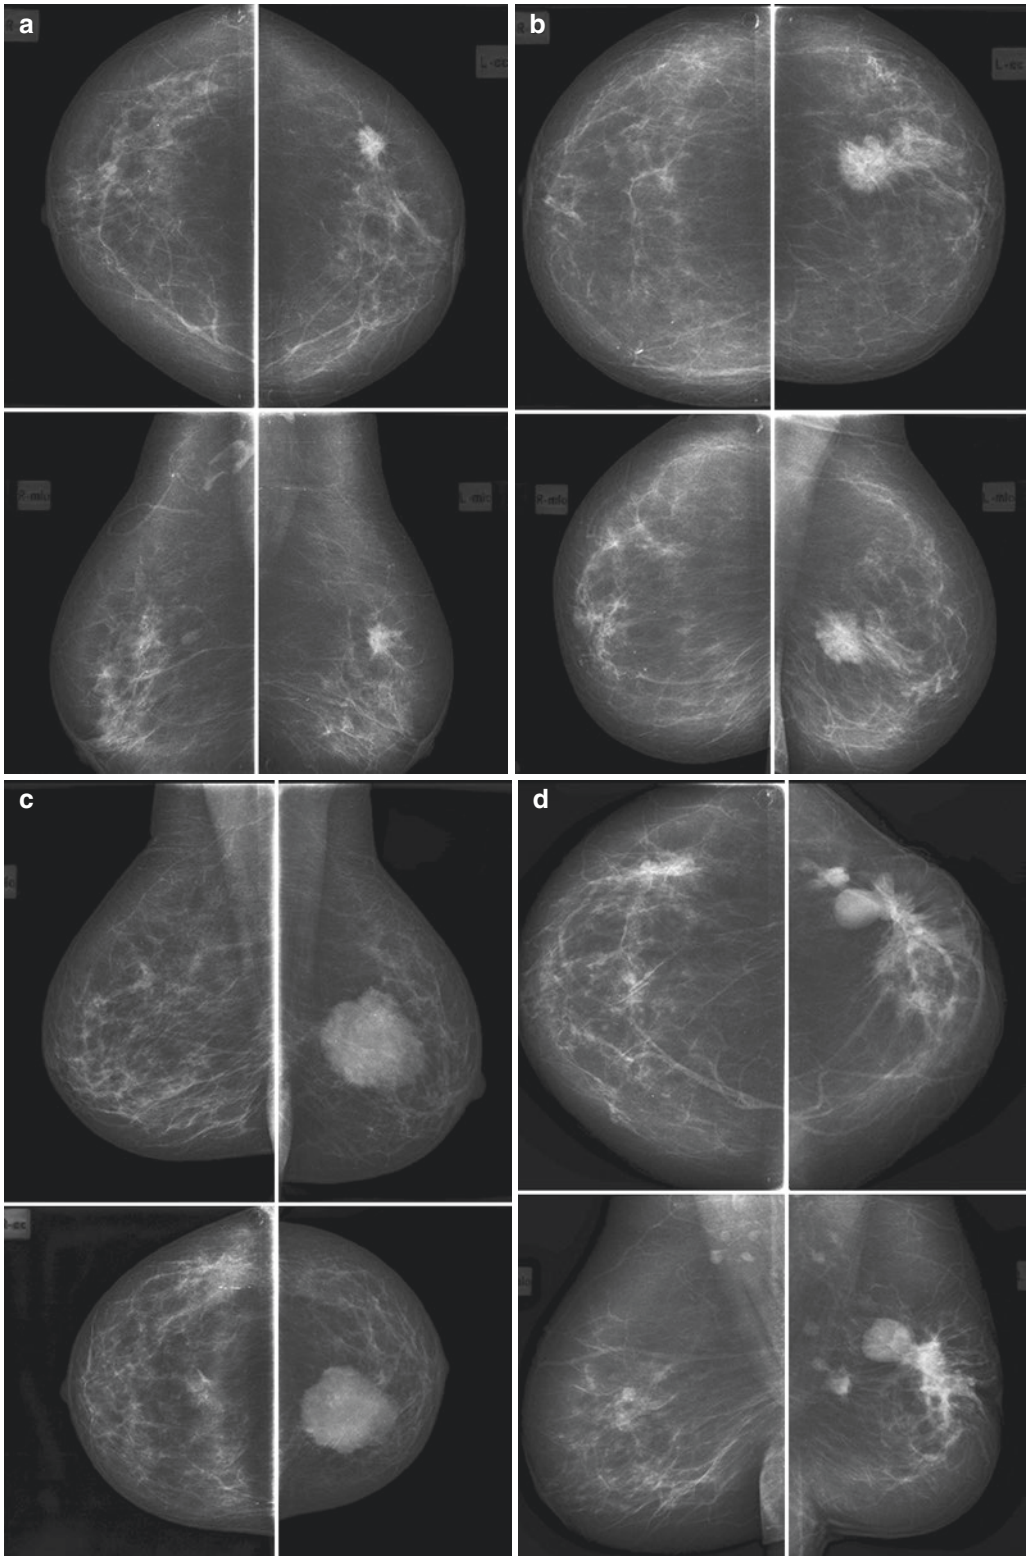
(a–h) X-ray mammography. Breast cancer
